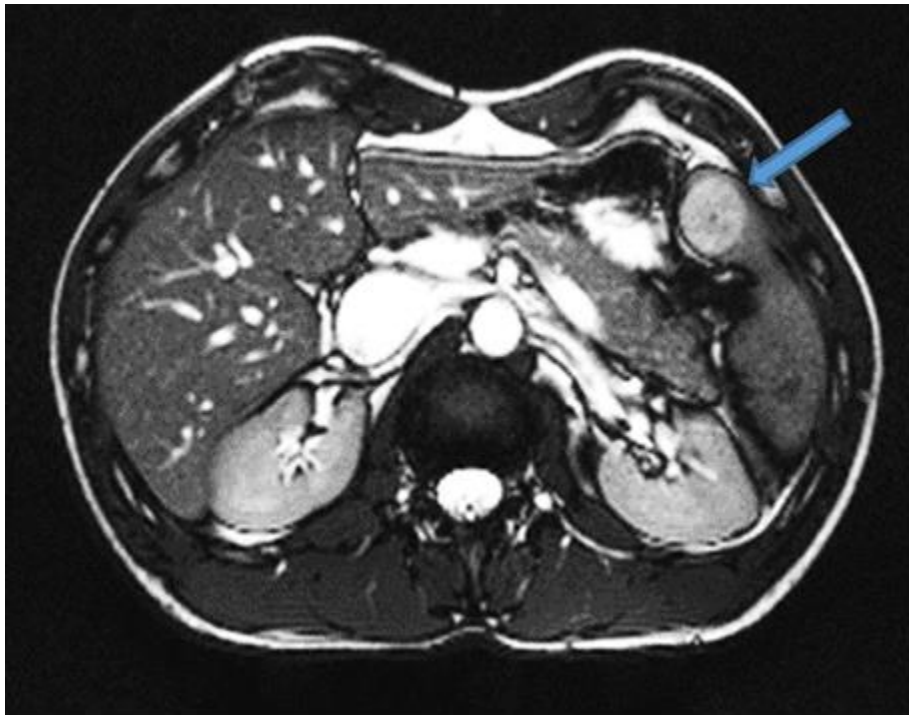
Magnetic resonance imaging examination showed a solitary lesion in the lower pole of the spleen, with peripheral rim enhancement on arterial phase
